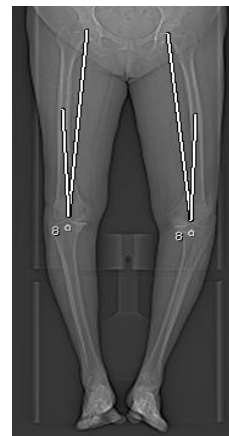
Preoperative CT Scanogram showing hip centre, knee centre and femoral mechanical axis, femoral anatomical axis and measurement of FMAA, in a patient undergoing bilateral total knee replacement surgery
